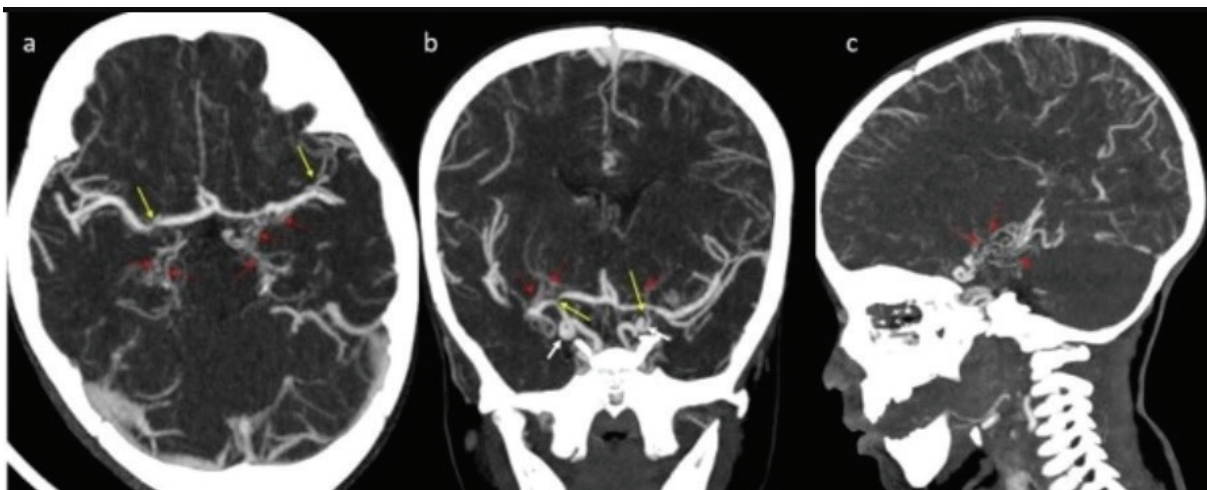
CT angiography examination, axial (a), coronal (b), and sagittal (c) planes; a, occlusions (yellow arrows) in the left MCA superior segment at the right ICA bifurcation level; b, bilateral tortuosity (white arrows) of the ICA, occlusions in the right ICA bifurcation segment and the left ICA supraclinoid segment (yellow arrows); in all three images, thin curvy collateral veins, Moyamoya veins are shown with red arrows
